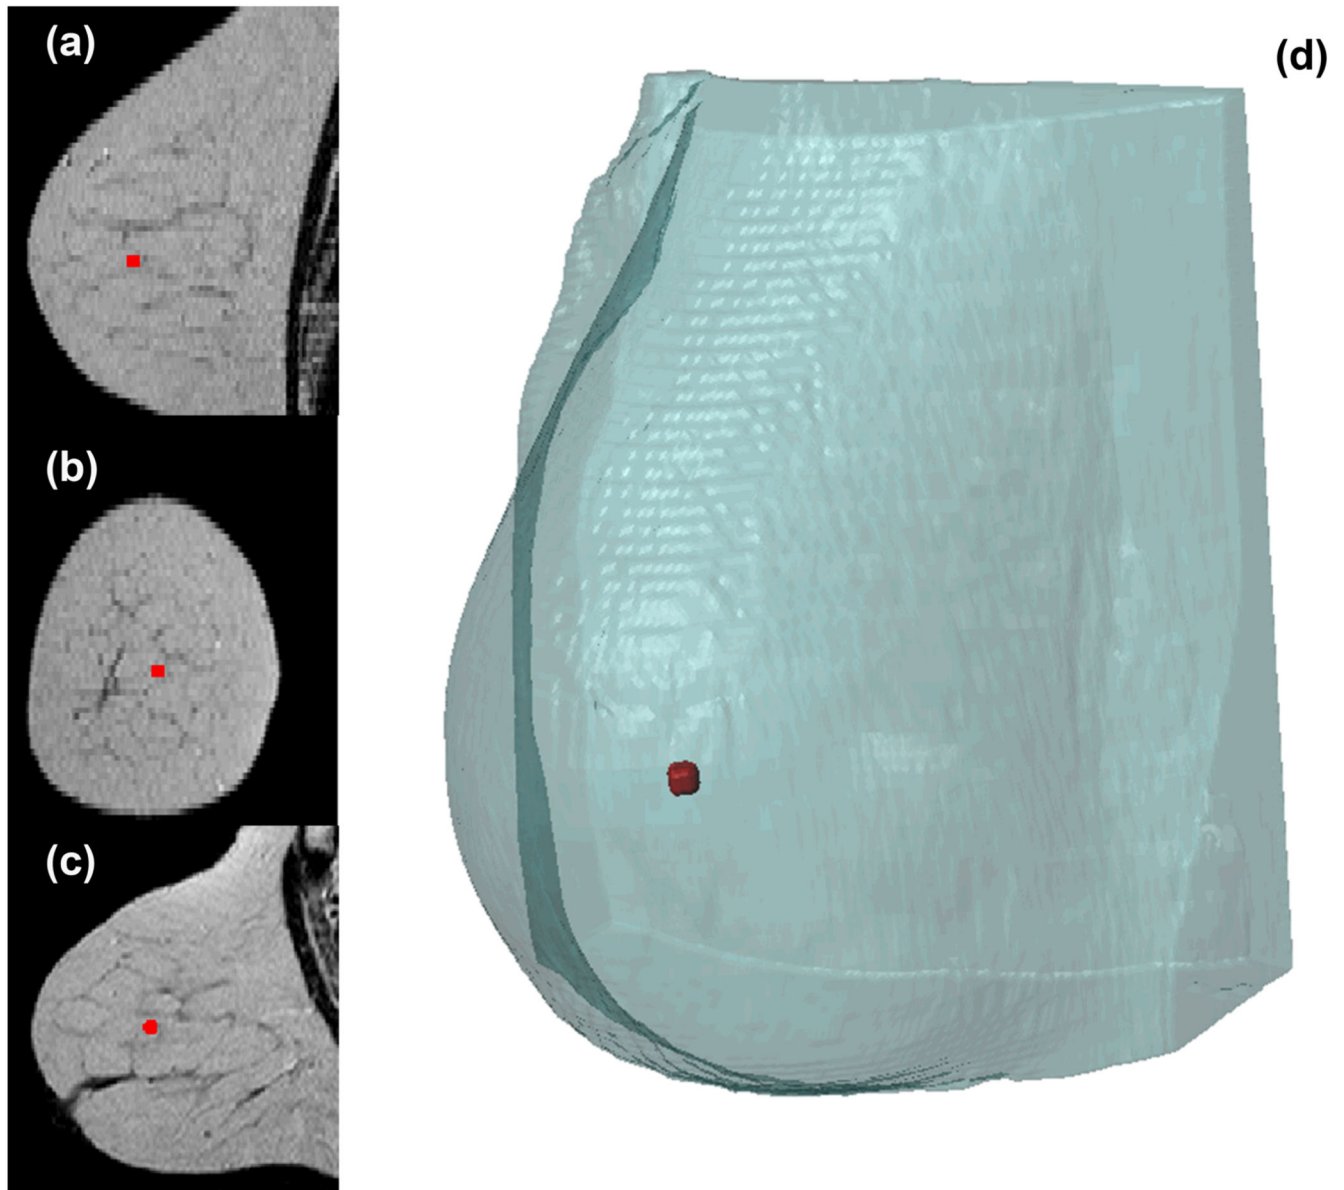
Sagittal (a), coronal (b), and axial (c) views of the acquired breast MR images. (d) Three-dimensional representation of the extracted mesh. The red colored region represents the position of the initial tumor seed.
